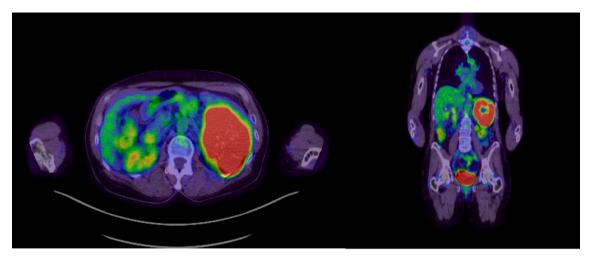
PET-CT scan showing splenic mass.
